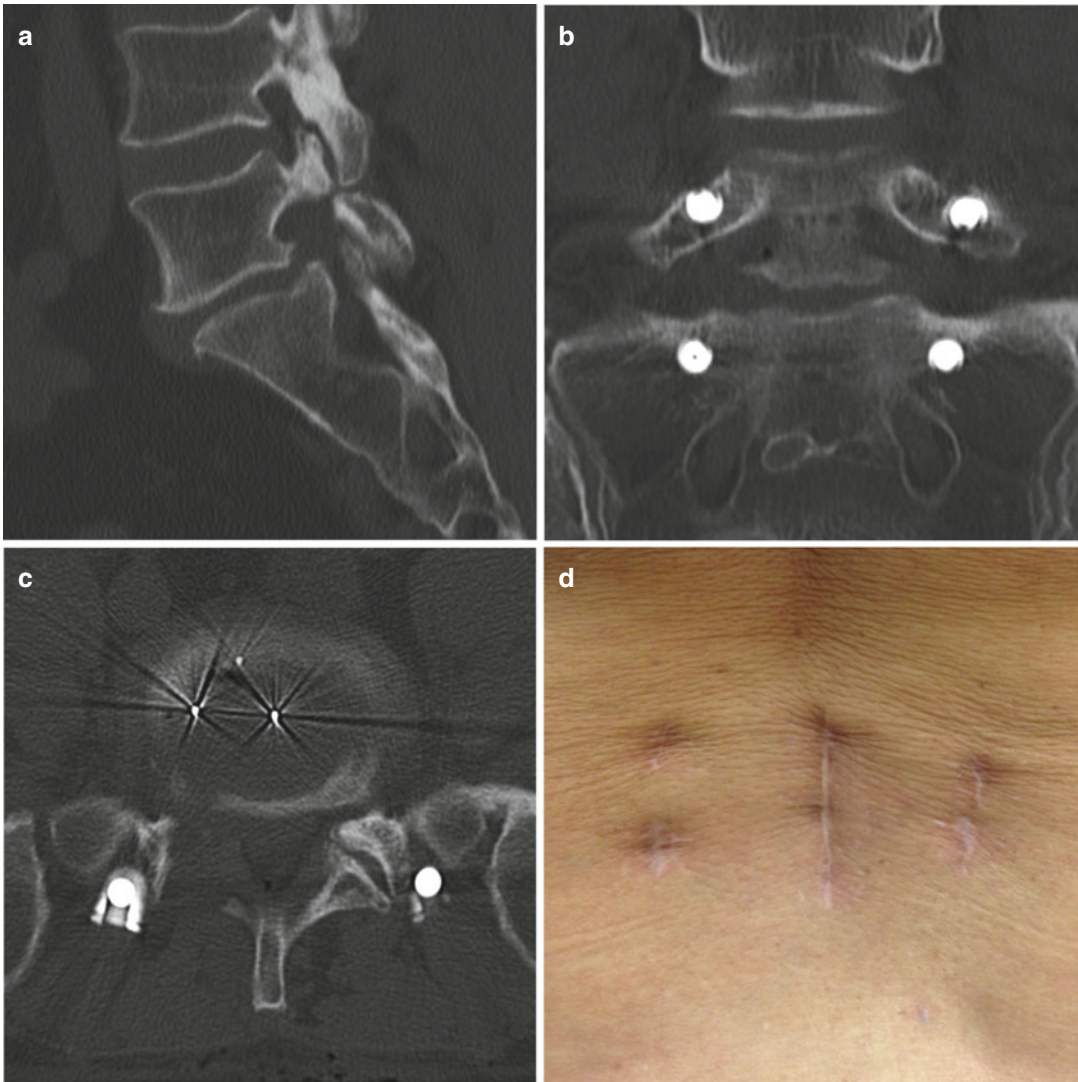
Example case of a 54-year-old isthmic L5/S1 spondylolisthesis grade I for MIS TLIF using SpineAssist. (a) Preoperative sagittal CT scans. (b) Pedicle screws, placed via SpineAssist on coronal CT scan. (c) Postoperative
